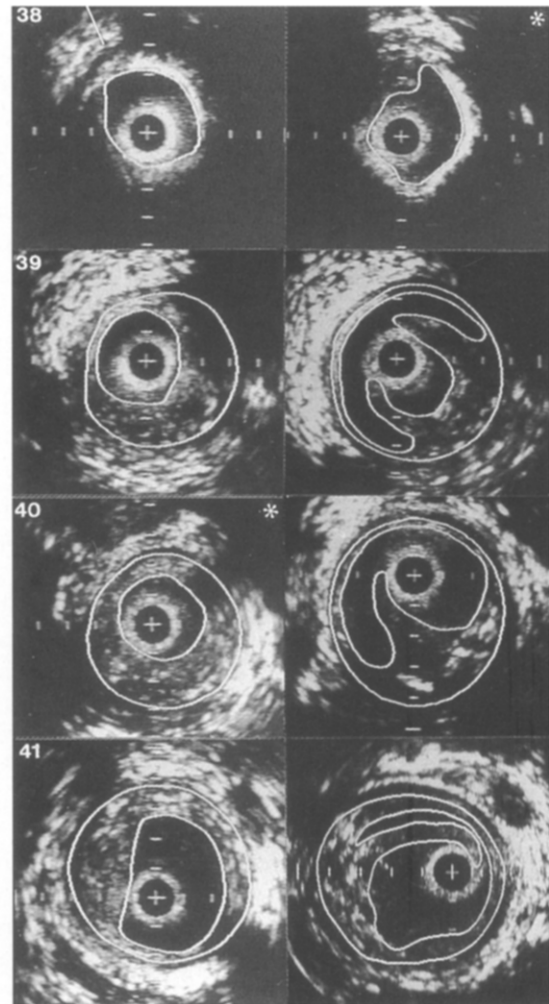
Corresponding intravascular ultrasound cross-sections obtained before (left) and after (right) balloon angioplasty (PTA) of the femoropopliteal artery. The intravascular ultrasound cross-sections are contour-traced off-line facilitating the recognition of lumen area (inner contour) and media-bounded area (MBA; outer contour). In the first corresponding cross-sections (level 38) the presence of a hard lesion prevented measurement of the MBA. Distally the lesion was classified as soft. Asterisk indicates the narrowest site. After PTA, dissections were seen + =catheter; calibration = 1 mm.
